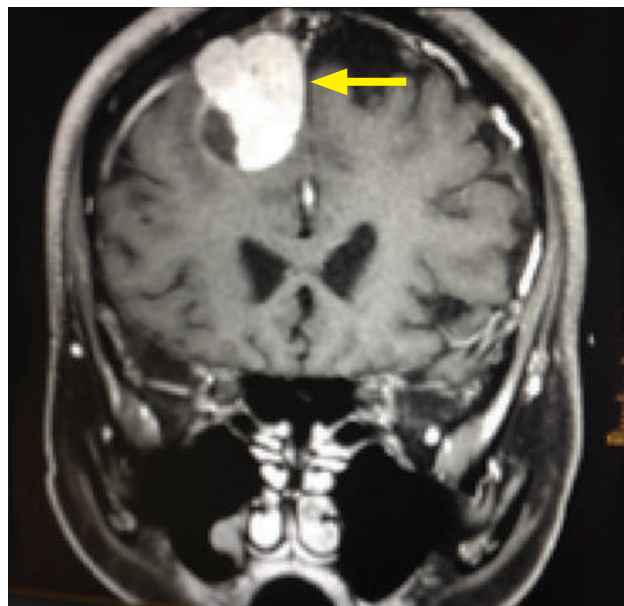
MRI of the brain showing a well-defined extra axial soft tissue mass in the right parietal lobe with cystic areas noted within the tumor.
